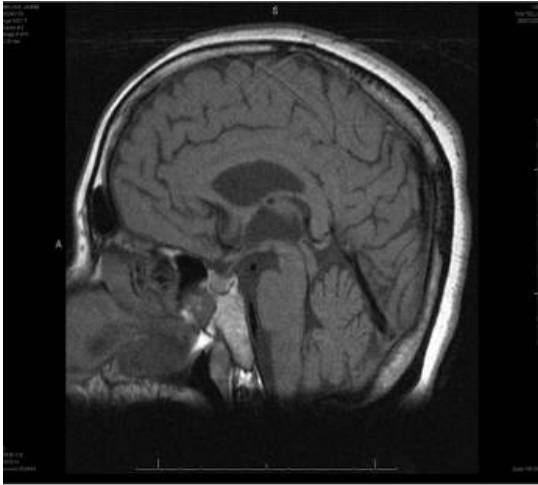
MRI pituitary: Showing a normal fossa
